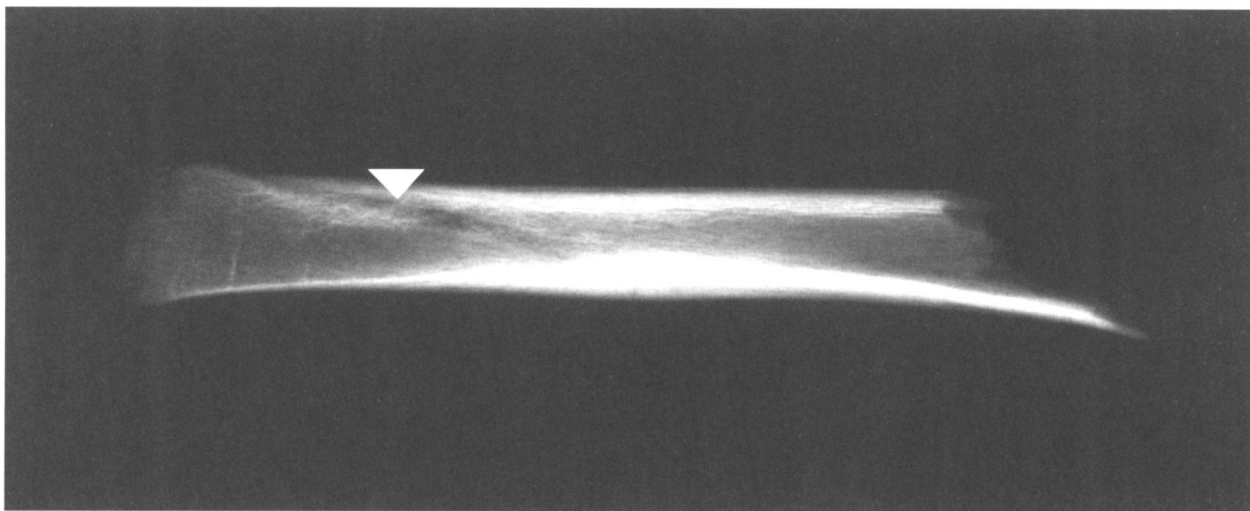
Skeleton 88. Radiograph of the affected bone demonstrating possible fracture line. Radiograph also revealed the presence of Harris lines
